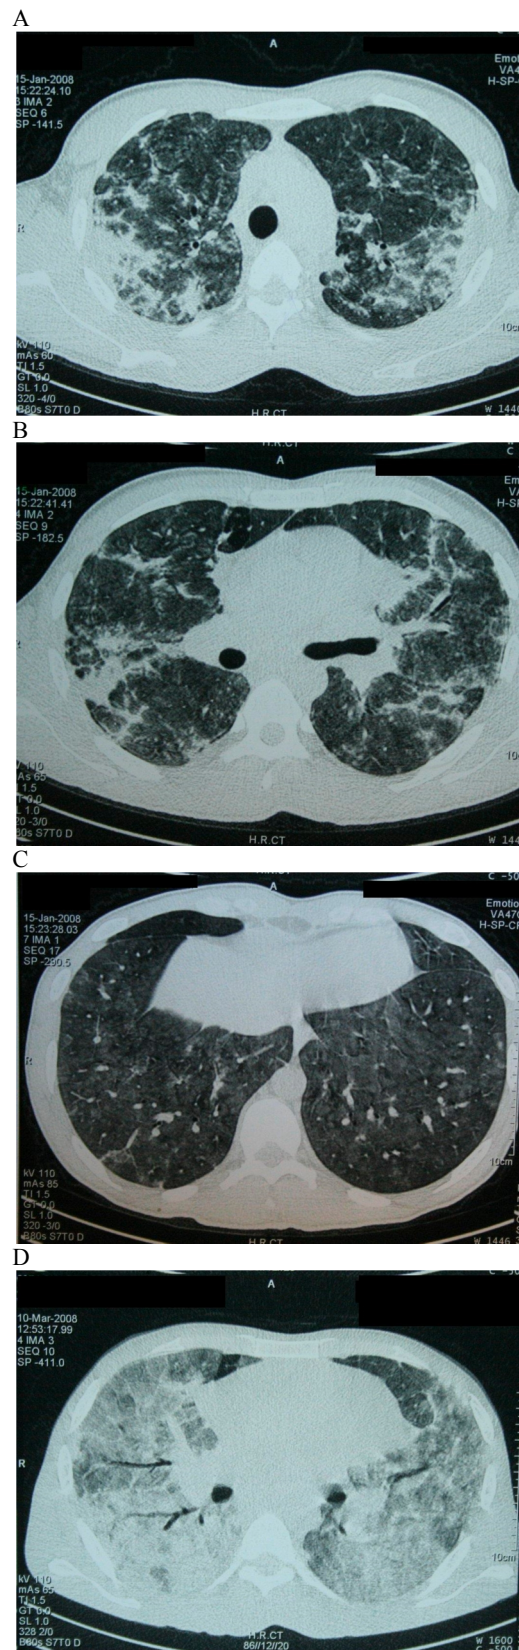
Patient's chest CT scans, 2 month before last admission (a-c) and last admission (d).
